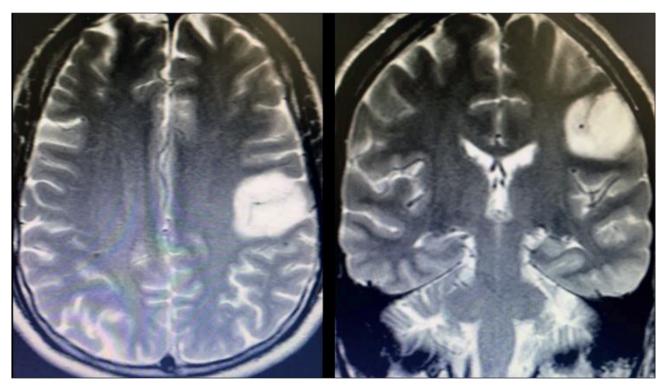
Magnetic resonance image from a male patient with 43 years old, permanent atrial fibrillation and restrictive cardiomyopathy. 40 minutes of symptoms onset. Next images are from the same patient performed at the same day.
